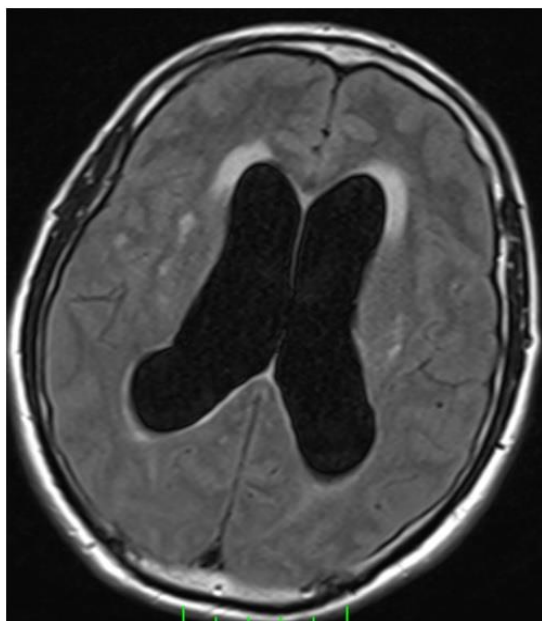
Preoperative cranial CT image.
